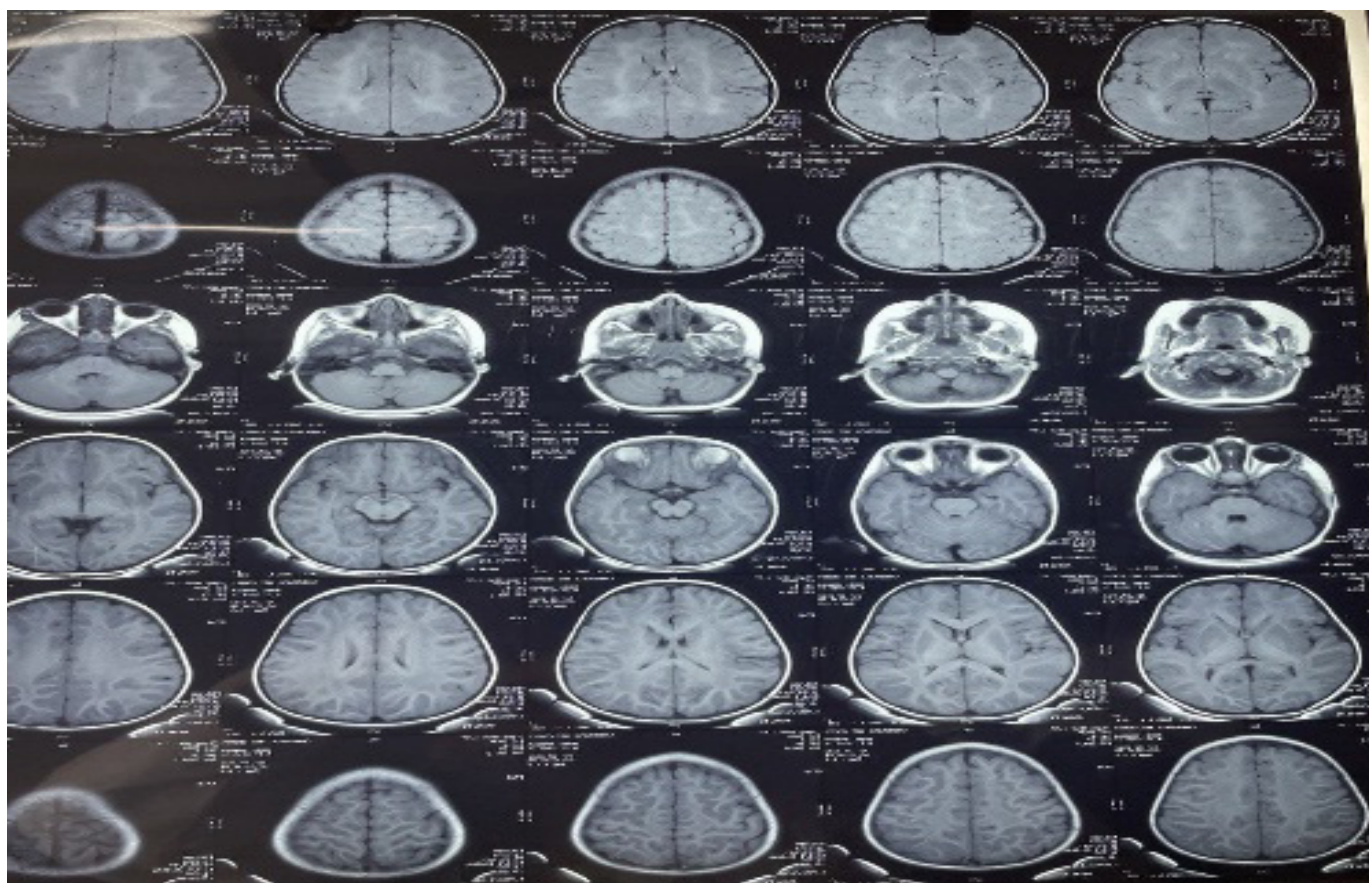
MRI brain suggestive of confluent t2/FLAIR hyperintensities with hypointense foci within (tigroid pattern) bilateral white matter with relative sparing of temporal lobe.
